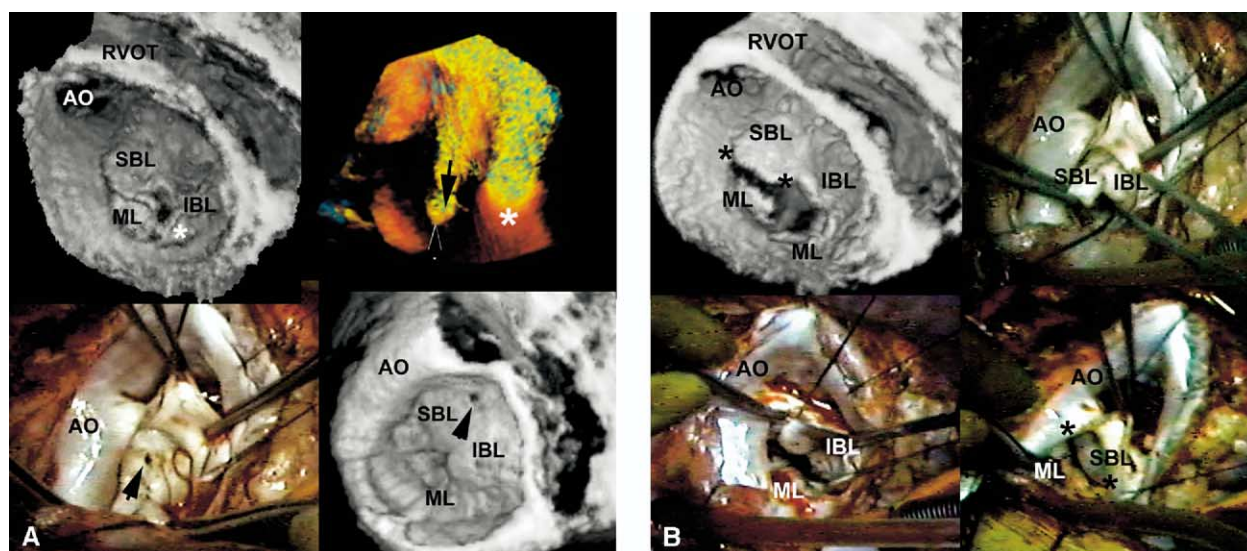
A, This montage is from patient 3 and demonstrates the sites of regurgitation. Note the residual hole in the surgical image at the base of the repaired cleft in the *lower left panel*, as indicated by the *black arrow*. The position of the aorta has been superimposed on the surgical image. This corresponds to that seen by means of 3D echocardiography in the *lower right panel*, as imaged from above in a surgical view. The *upper left image* is the LAVV as seen from below during systole. Note the residual defect in the vicinity of the inferior and mural leaflets, as indicated by the *white asterisk*. The *upper right panel* represents the 2 regurgitant jets with the tissue stripped away. Note the smaller jet (*black arrow*) from the residual hole and the larger jet (*white asterisk*) from the posteroinferior region. AO, Aorta; IBL, inferior bridging leaflet; ML, mural leaflet; RVOT, right ventricular outflow tract; SBL, superior bridging leaflet. B, This panel of images is also from patient 3 and demonstrates the commissures of the LAVV as seen from a surgical and 3D perspective (diastolic view from below by means of echocardiography). Note the well-formed commissure between the superior and mural leaflets, both in the surgical image in the *lower right panel* and the 3D image in the *upper right panel*, which are seen between the 2 asterisks. The *lower and upper left panels* show the poorly formed inferior and mural commissure, which was the site of the major regurgitant jet. Also note the tiny residual cleft in the LAVV. The position of the aorta has been superimposed on the surgical view. AO, Aorta; IBL, inferior bridging leaflet; ML, mural leaflet; RVOT, right ventricular outflow tract; SBL, superior bridging leaflet.
